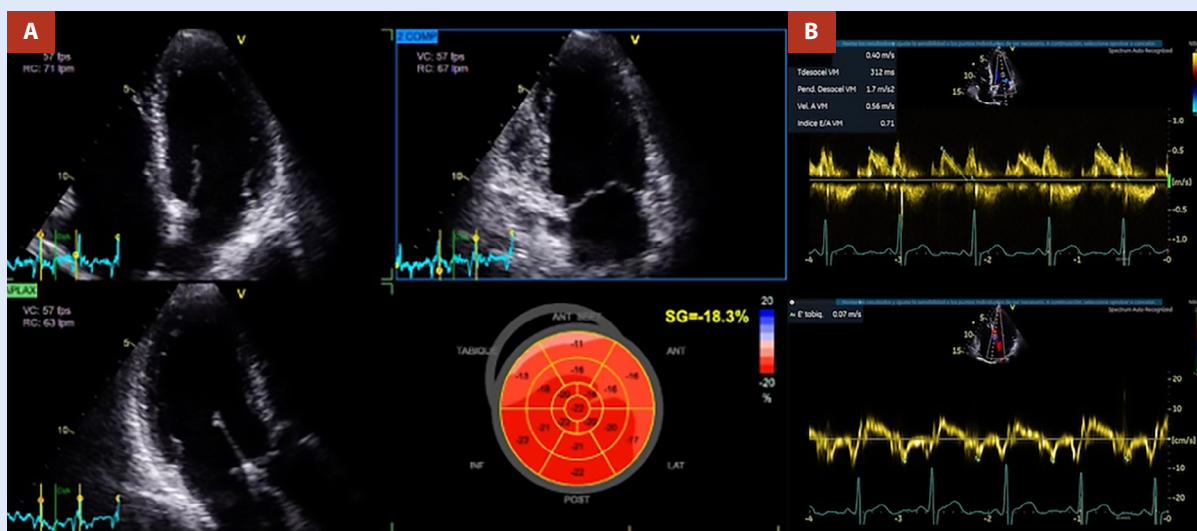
Enlital transthoracic echocardiogram. A. Four-chamber, two-chamber, and three-chamber views of the left ventricle (LV) with normal volumes and preserved LV ejection fraction (LVEF) of 58%. B. Prolonged relaxation pattern of the LV and an E/e ratio of 5, consistent with the absence of increased LV filling pressures.
